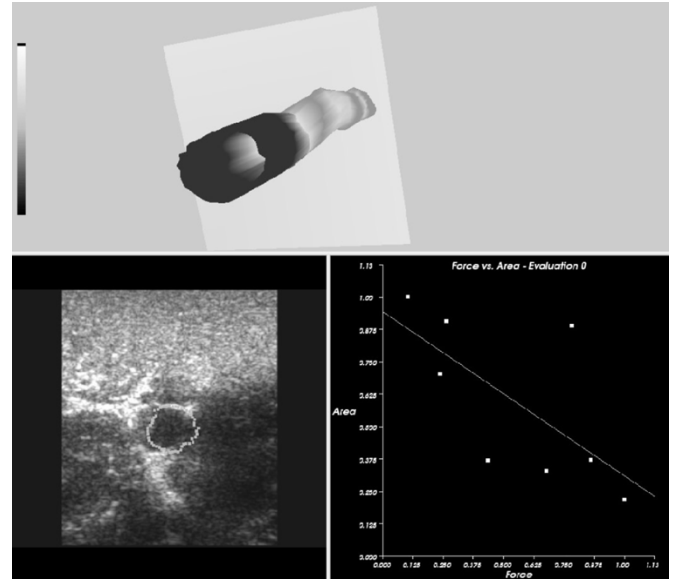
Screen shot showing constructed model (top), with ultrasound data and detected contour (bottom left) and compression assessment (bottom right) for area indicated by virtual plane on the constructed model. Data from a healthy femoral vein from volunteer; dark indicates missing data.
